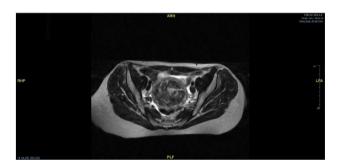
MRI of the pelvis (DEFS T2 TRS).
